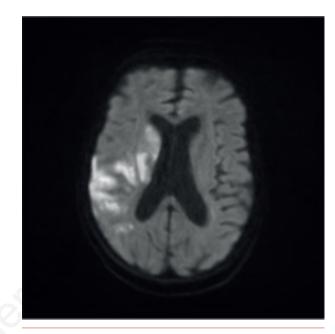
Magnetic resonance imaging of the brain shows extensive right cerebral infarcts.
